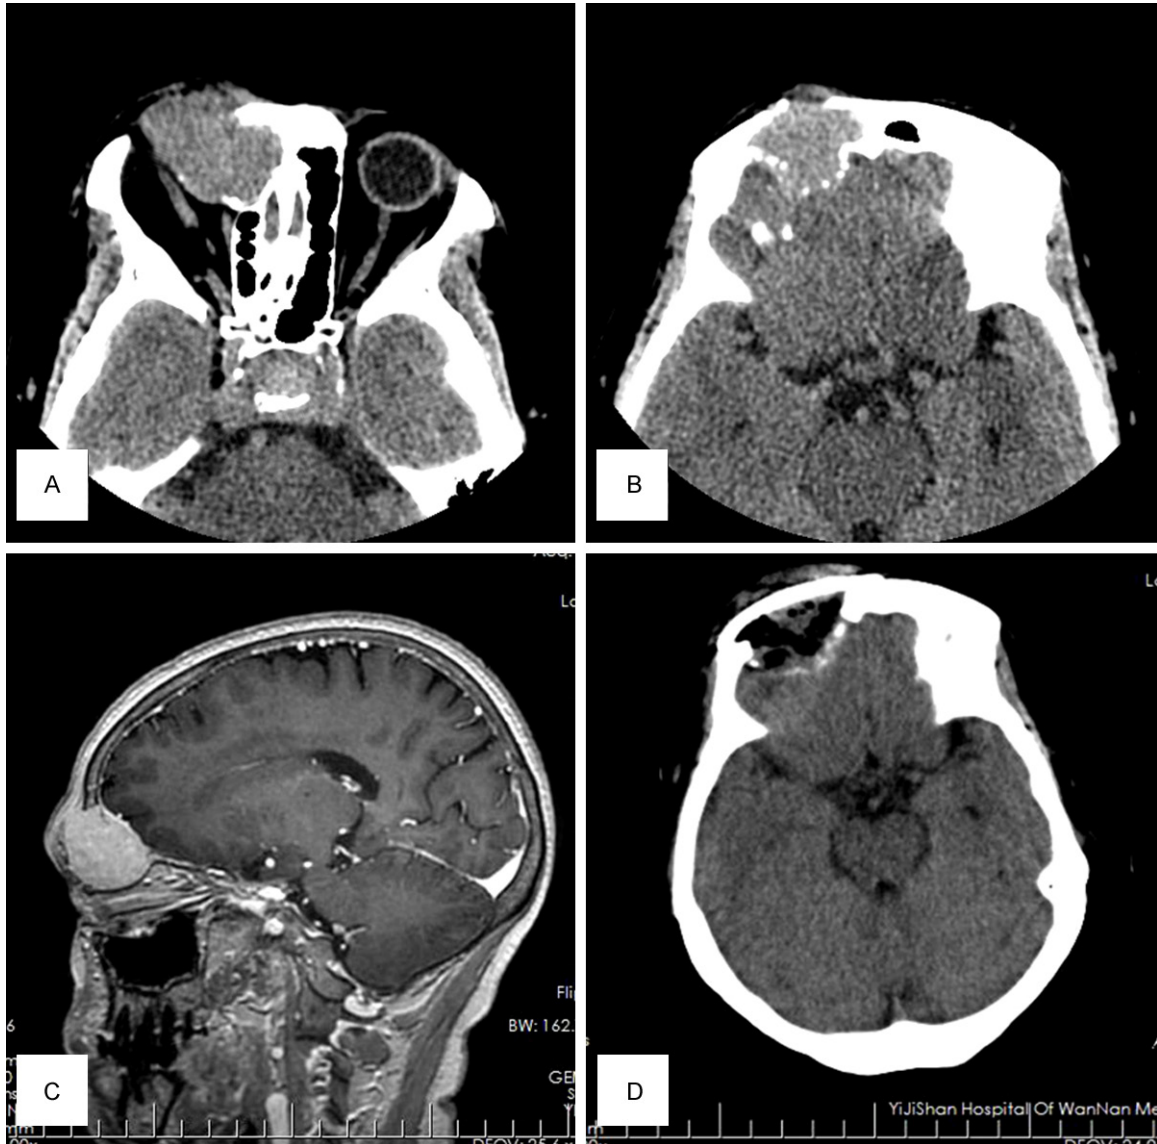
A, B. Orbital CT revealed an isodense tumor with osteolytic characteristic in the right orbit and frontal sinus. C. MRI of the brain disclosed a 2.8×3.4×3.5-cm homogeneously enhanced, well-demarcated extradural mass. D. Postoperative CT of brain revealed both the tumor and invaded bone were total resected and cranioplasty was performed with digital shaping titanium mesh.
